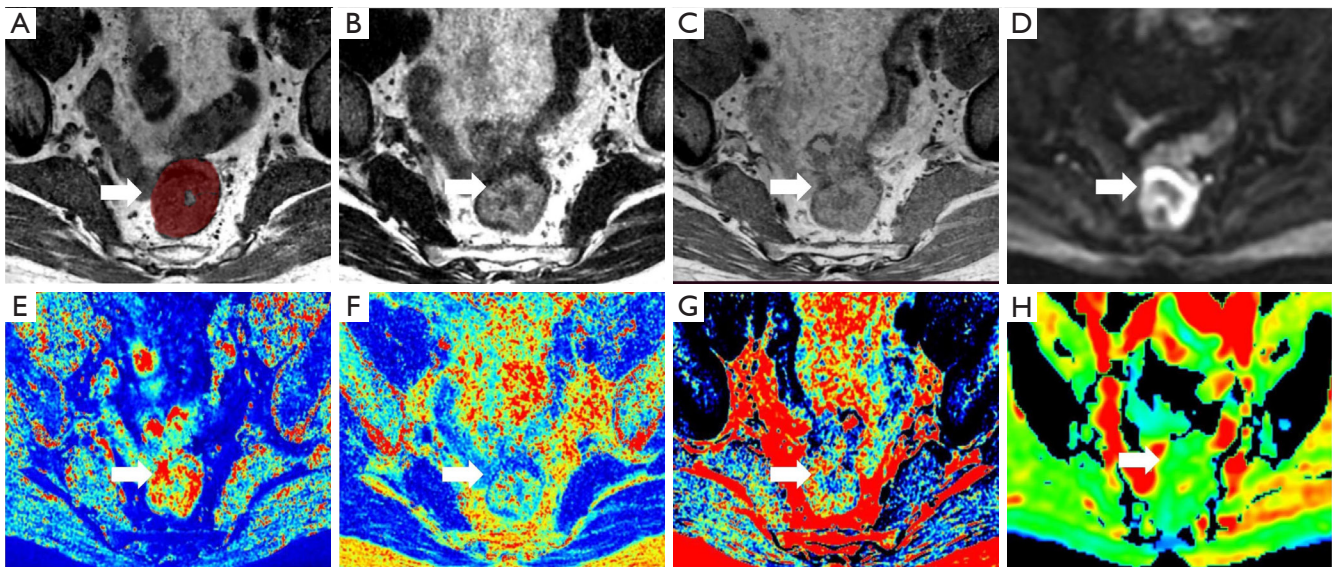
A 45-year-old man with poor differentiation RC [T2N0, mesorectal fascia (-), extramural venous invasion (-)]. (A-C) synthetic T1-, T2-, and PD-weighted images, respectively; (D) axial DWI ($b=800 \text{ s/mm}^2$); (E-G) T1, T2, and PD maps derived from SyMRI indicating the mean T1, T2, and PD values, which were drawn along the contour of the tumor on the slice with the largest tumor diameter were 1,103 ms, 72 ms, and 70 pu, respectively. (H) ADC map indicates that the mean ADC value was $1,315 \times 10^{-6} \text{ mm}^2/\text{s}$. The arrow points to the tumor. RC, rectal cancer; PD, proton density; DWI, diffusion-weighted imaging; SyMRI, synthetic magnetic resonance imaging; ADC, apparent diffusion coefficient.
